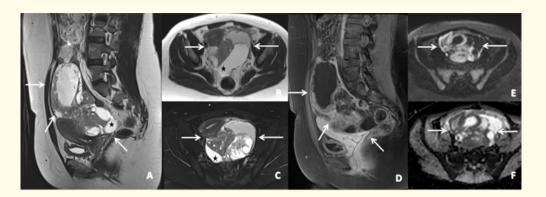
Showing a large pelvic heterogeneous cystic mass extending to the mid abdomen on MRI pelvis. Mass is compressing the uterus and urinary bladder (arrows) anteriorly and sigmoid colon posteriorly with minimal pelvic free fluid (black star) (a-c), and shows post-contrast enhancement (arrows) (d) with significant restricted diffusion at its solid parts (arrows) (e, f). Both ovaries cannot be separated from the mass.
